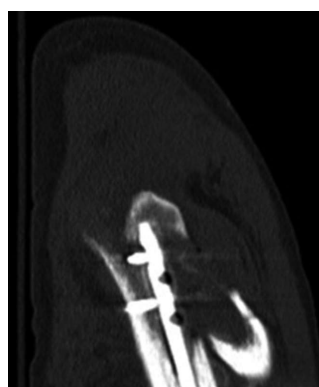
Sagittal computed tomography scan image showing the fracture at the screw insertion site.
